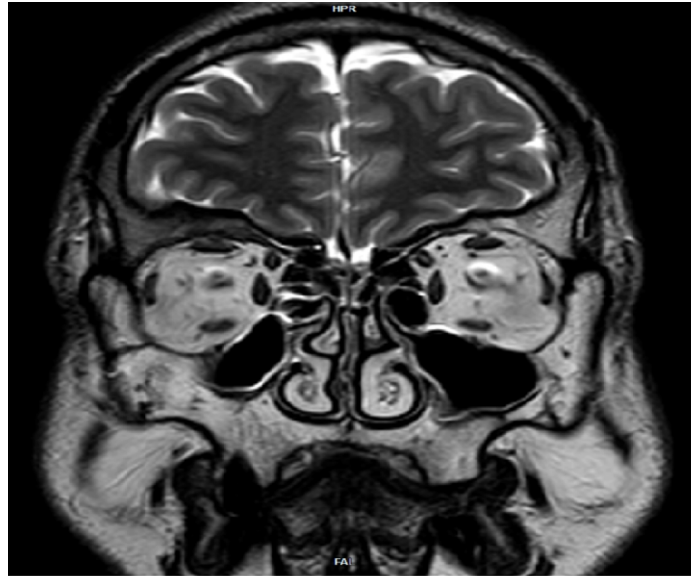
Magnetic resonance imaging (18 months later): coronal T2-weighted head scan showing complete disappearance of the solid mass
